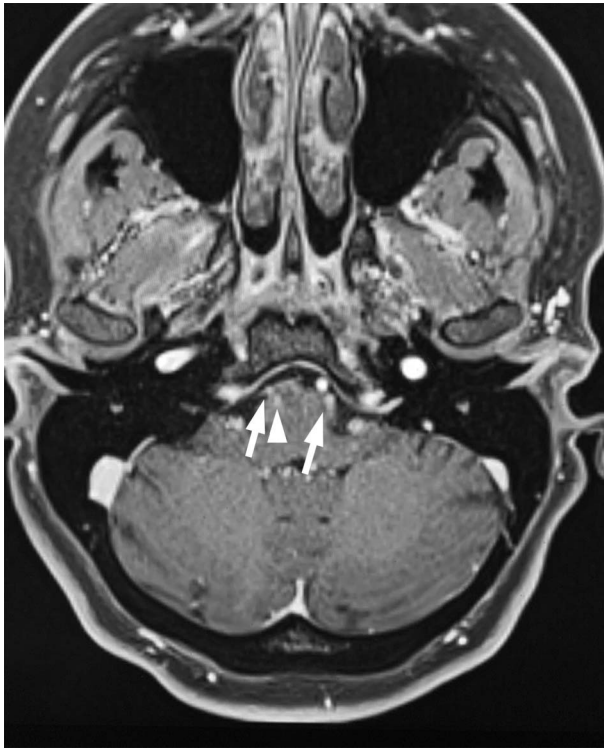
MRI demonstrating bilateral inflammatory abducens neuritis. High-resolution postcontrast T1 axial VIBE image of the skull base shows bilateral enhancement of the proximal abducens nerve (arrows). There is an additional focus of brainstem enhancement involving the right abducens nerve root entry zone at the pontomedullary junction (arrow head).
